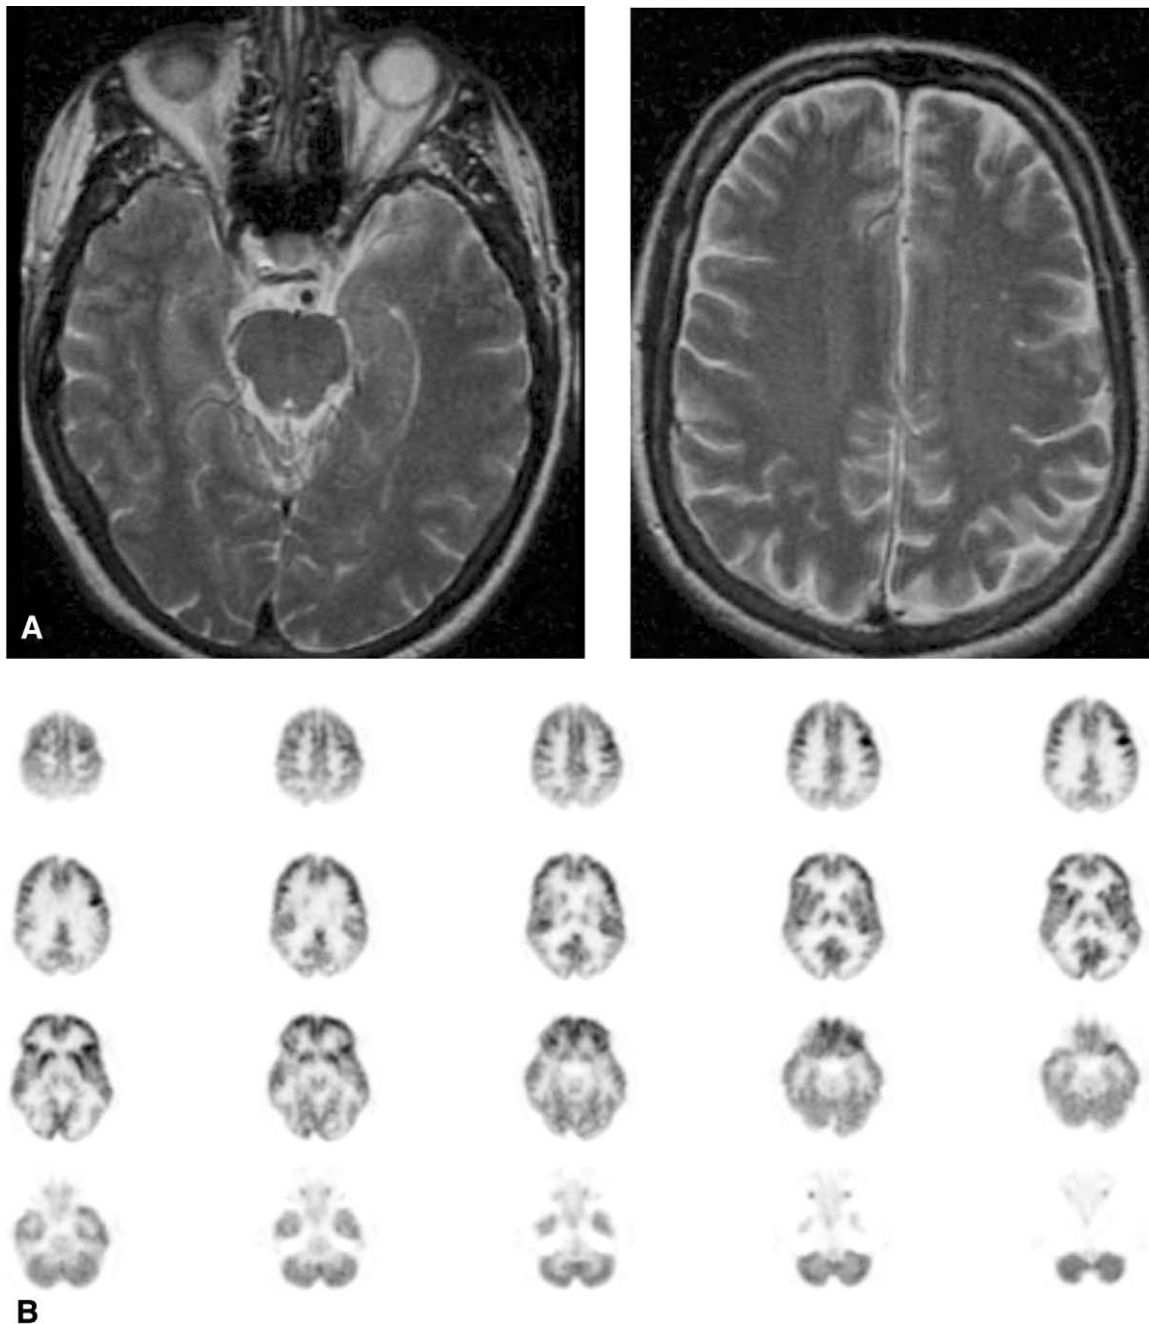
Diffuse Lewy body disease: A 65-year-old man presenting with a history of new-onset visual hallucinations, depression, mild gait disturbance, and progressive cognitive impairment. (A) Magnetic resonance imaging taken 1 week before the positron emission tomography study was unremarkable. (B-D) The positron emission tomography with 2-deoxy-fluoroglucose (axial, coronal, sagittal planes) study demonstrates significant bilateral hypometabolism in the temporal and posterior parietal lobes as well as the occipital cortex (arrows).
